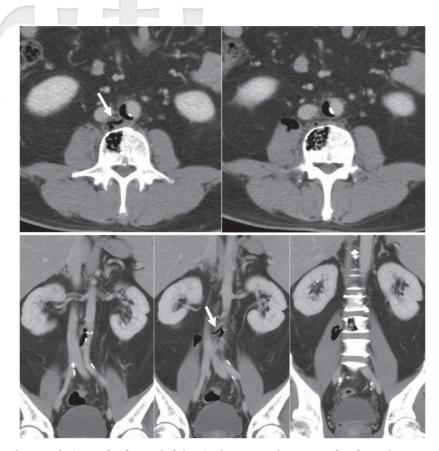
The axial and coronal views of enhanced abdominal computed tomography showed gas accumulation beneath the atherosclerotic plaque of the abdominal aortic wall, L3 vertebral body, and right psoas muscle. A gas-filling fistula tract was also found (arrows).
